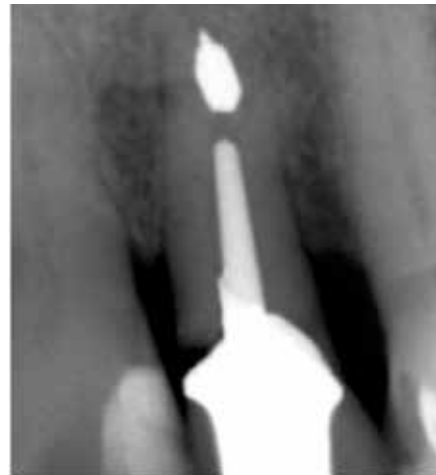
Radiograph of fractured tooth.
